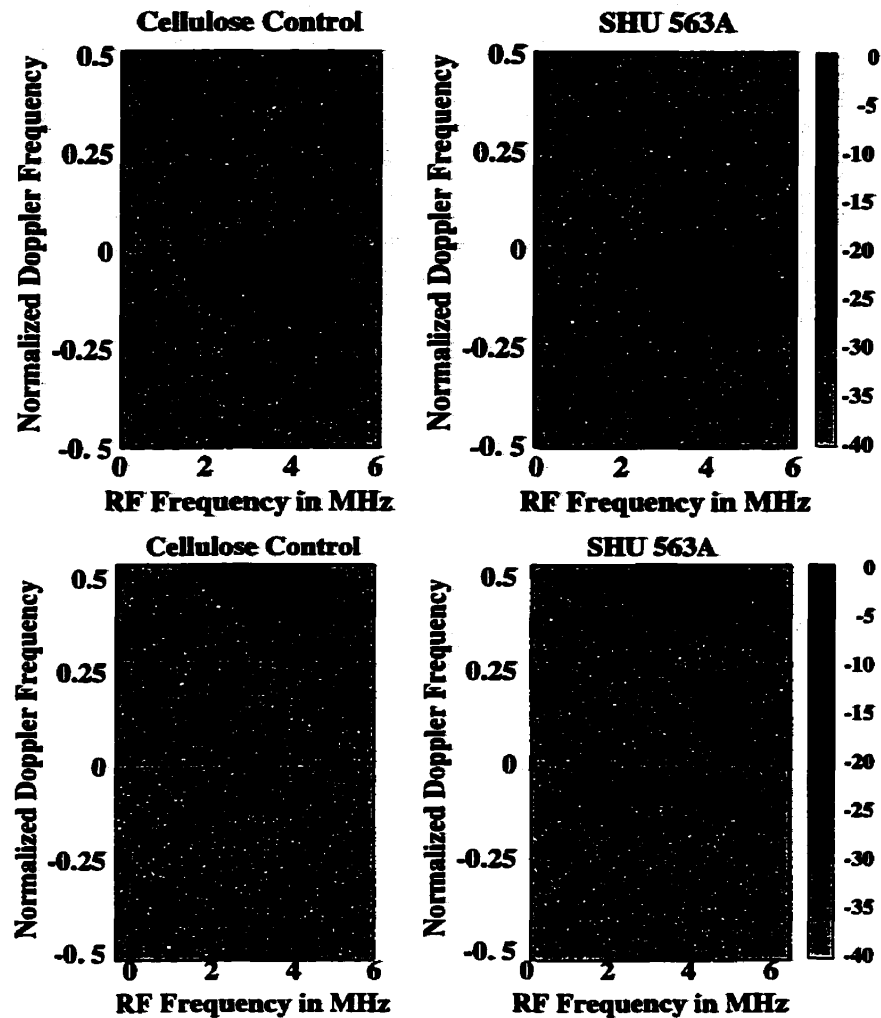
Echo power in dB as a function of Doppler and RF frequency for Broadband Pulses: 1 cycle, 2.9 MHz, 1.2 MPa transmit pulsing; TOP: conventional Doppler; BOTTOM: pulse inversion Doppler. The negative half of the RF spectrum in each case (not shown) was identical to the positive half, but with inverted Doppler shifts. Broadband pulse inversion Doppler can operate over the entire spectrum of the RF echoes.
